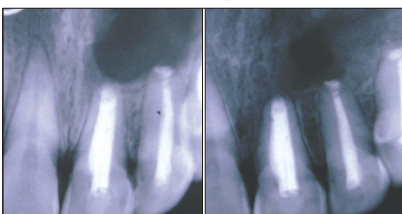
Seven days post operative radiograph Fig. 33 : Six months post operative radiograph
